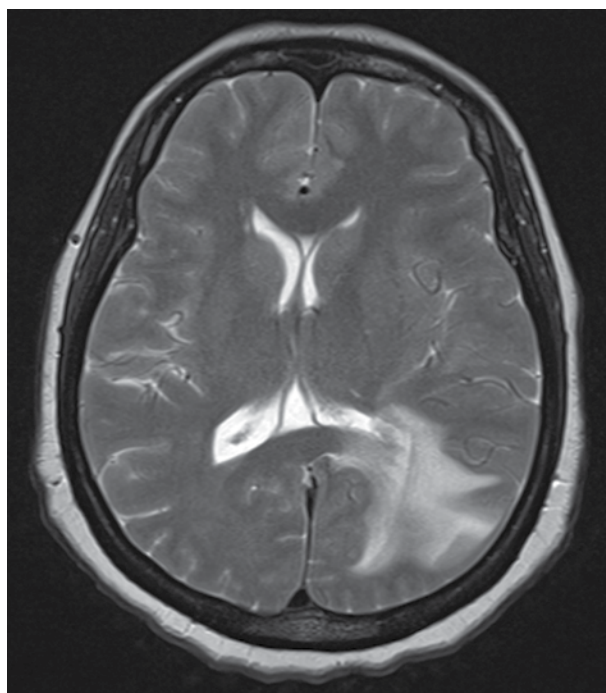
MRI brain scan – enhancing lesions within the occipital lobes bilaterally and the left temporal lobe.
